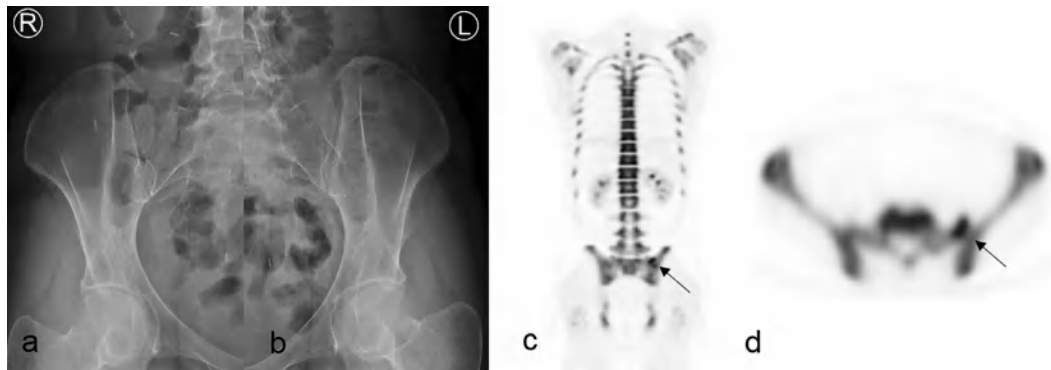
Sacroiliac joint oblique X-ray and  $^{18}\text{F}$ -NaF positron emission tomography/computed tomography images of a 48-year-old patient with chronic lower back pain who tested negative for serological human leucocyte antigen B27 and did not meet the Assessment of SpondyloArthritis International Society criteria for ankylosing spondylitis. Conventional X-ray was not indicative of sacroiliitis (a, b). However, increased uptake at the left sacroiliac joint on the F-18 NaF positron emission tomography/computed tomography image was observed (c, d) and the patient was considered false negative according to Assessment of SpondyloArthritis International Society criteria.
